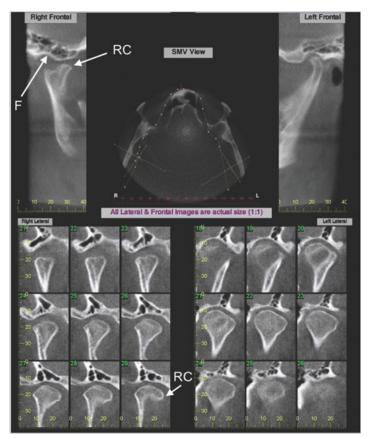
A TMJ series from a CBCT scan showing the regenerated condyle
